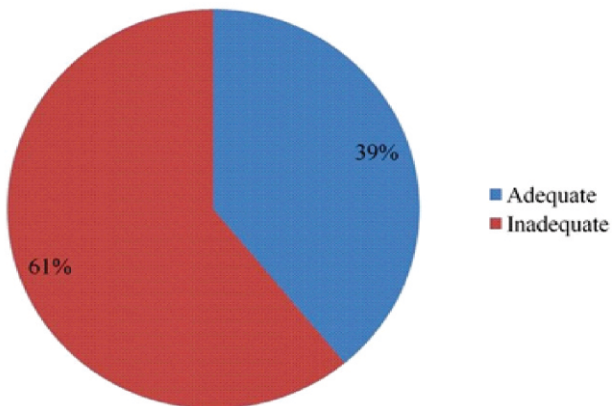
Total CT Contrast Performed in the 1st Week of December (02-12-2019 to 07-12-2019)
